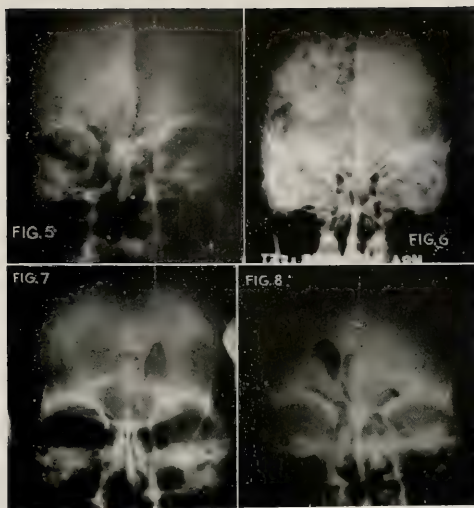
Roentgen films taken following encephalography in the anterior-posterior, posterior-anterior, right lateral and left lateral positions demonstrating the following:
